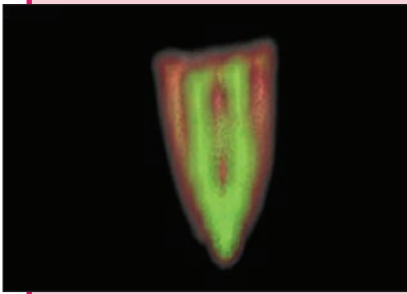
Computed tomography (CT) image of mesiobuccal and mesiolingual canals with root-filling material in place.
